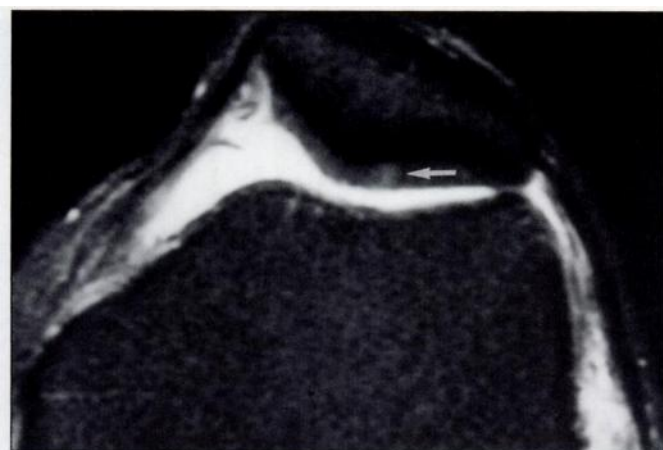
38-year-old man with medial knee pain. Axial T2-weighted fast spin-echo image with fat saturation (TR/TE, 3200/54) reveals area of increased signal intensity without surface irregularity of patellar cartilage (*arrow*) that was interpreted as grade 1 lesion on MR imaging but was not reported on arthroscopy.
